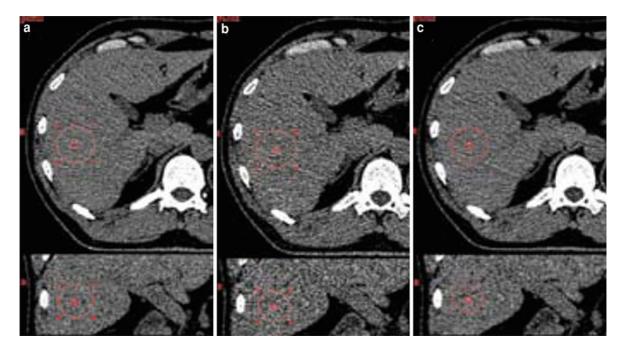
Effect of Quantum Denoising Software on a liver scan. a shows a scan at standard X-ray exposure and noise level. b shows a scan at 45% lower mAs. The noise value is
